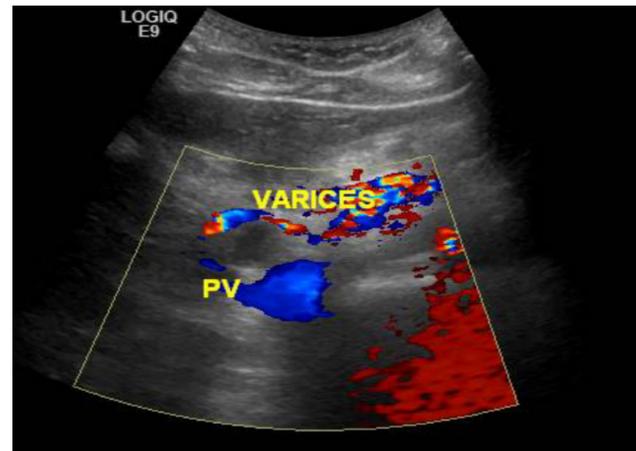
RUQ ultrasound showing the occlusion of the portosplenic confluence
